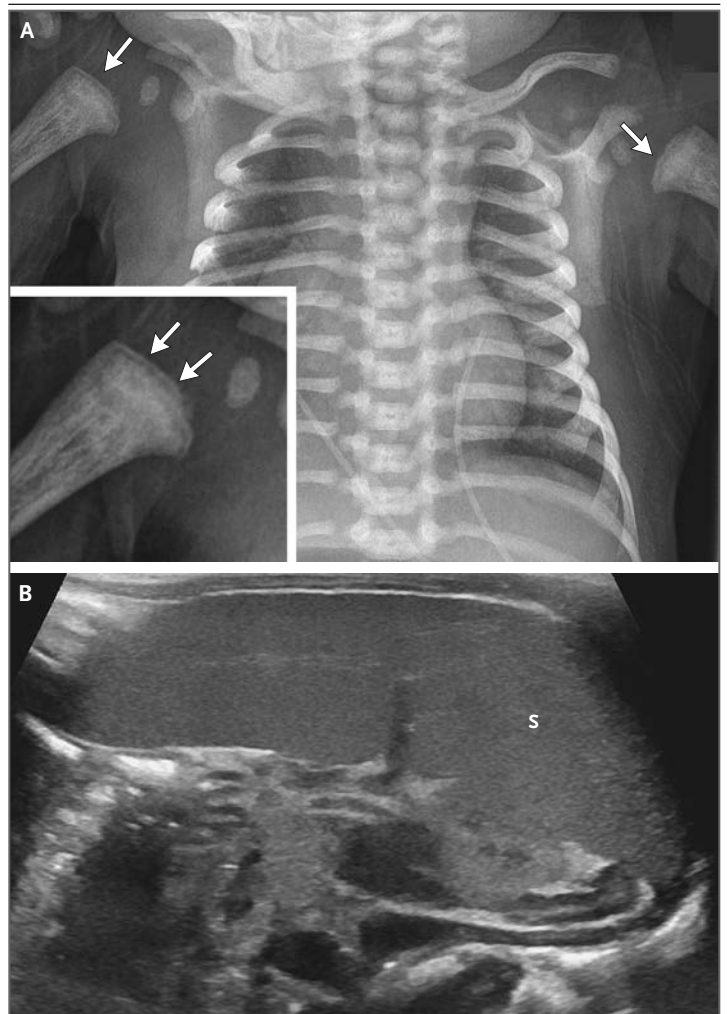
Chest Radiograph and Abdominal Ultrasound Image.
